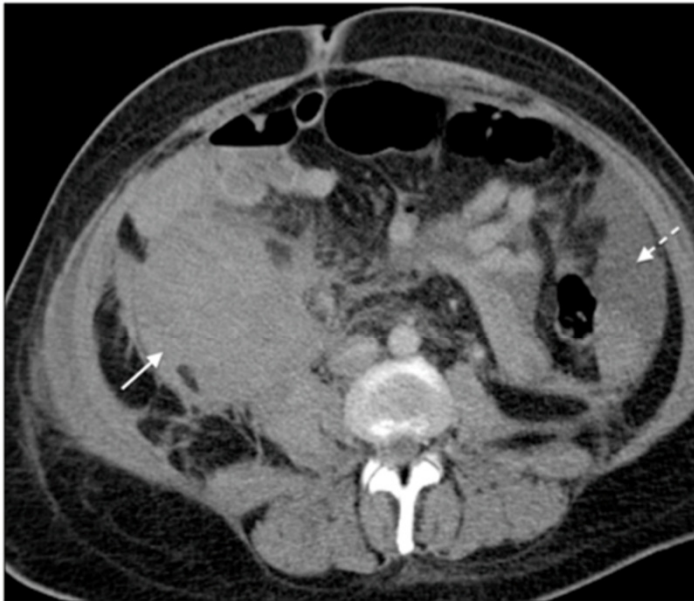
CT demonstrates a large right sided retroperitoneal haematoma (solid white arrow) and intra-abdominal free fluid consistent with haemorrhage (interrupted white arrow).
